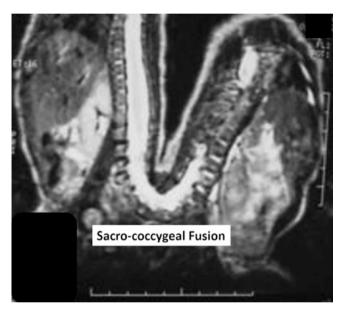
MRI is used for the assessment of the internal anatomy
